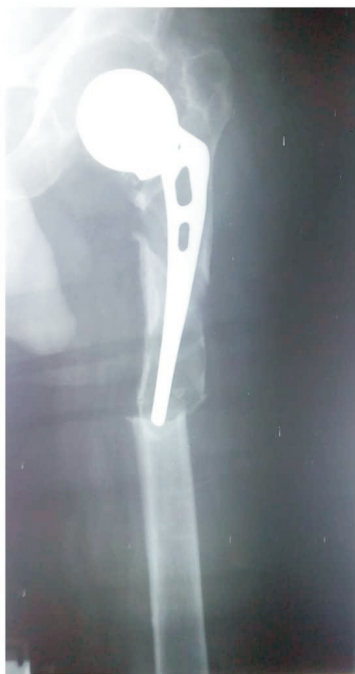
Pre-op plain radiograph of patient 1
